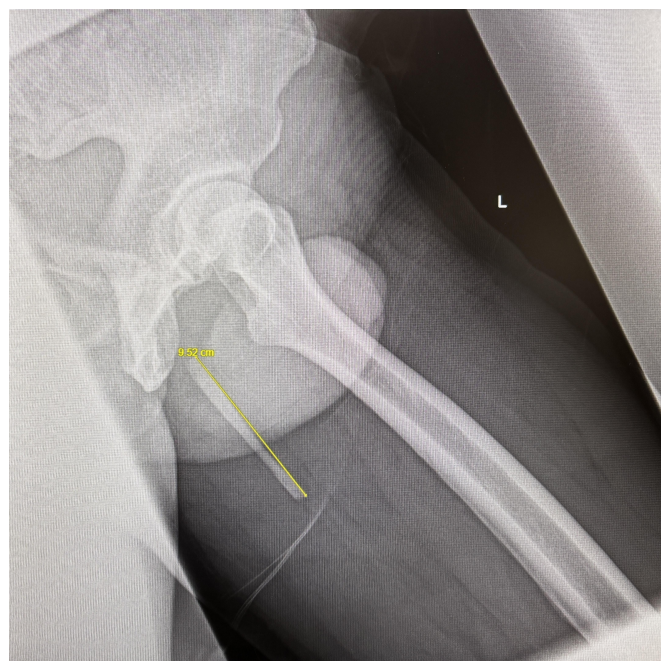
Repeat pelvic radiograph at six-month follow-up demonstrating minimal interval change in the linear calcific deposit within the proximal semimembranosus tendon, now measuring 9.52 cm.
